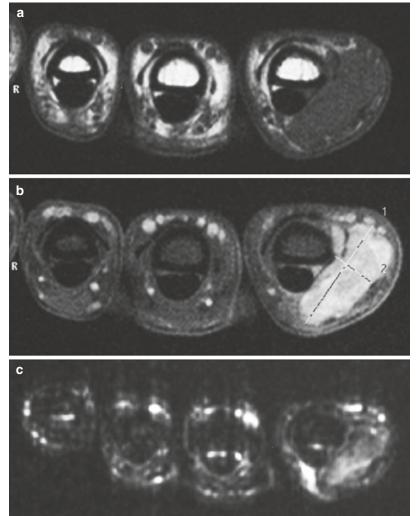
(a–c) Fibroma of the tendon sheath at the volar aspect of the index finger adjacent to the flexor tendon. (a) Axial spin-echo T1-weighted MR image. (b) Axial spin-echo T1-weighted MR image after gadolinium contrast injection with fat suppression. (c) Axial spin-echo T2-weighted MR image with fat suppression. The lesion is of low SI on T2-weighted MR images (c) and enhances moderately after gadolinium contrast injection (b)
